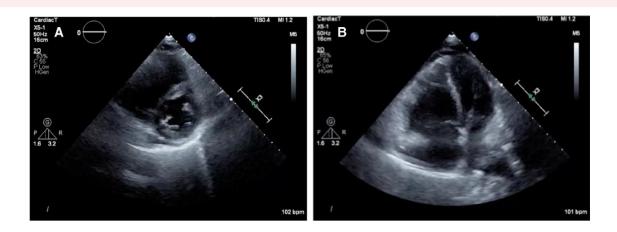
Echocardiography on the day of admission. Left sternal border short-axis view (A) and apical four-chamber echocardiographic view (B) demonstrate a D-shaped left ventricle and high tricuspid regurgitation peak gradient (TRPG, 57 mmHg). TRPG, tricuspid regurgitation peak gradient.
